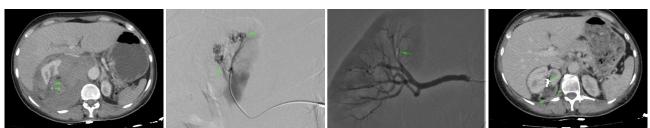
A) Axial section CT image of the patient admitted to the emergency department with acute abdominal pain. A large hematoma with active extravasation in the upper pole of the right kidney (arrows) is observed. B) In the renal artery angiography examination performed under emergency conditions; super selective images taken from the upper pole of the right renal artery show tumoral vascularity (arrows) due to angiomyolipoma in the upper pole of the right kidney. C) Postembolization angiography image showed the tumor was embolized completely with the coil (arrows) super selectively. D) In the control CT image of the patient 3 months later, it is seen that the coils (arrows) in the right kidney near the angiomyolipoma (arrowheads) and the hematoma disappeared after the embolization procedure.
